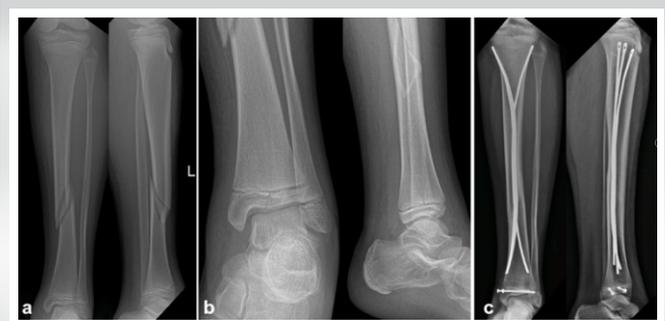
(a) Long-leg AP and lateral radiographs taken on presentation, showing spiral tibia shaft fracture with normal-looking ankle. (b) Dedicated ankle AP and lateral images show undisplaced triplane fracture. (c) Final AP and lateral radiographs following Enders nailing for tibia and percutaneous screw fixation for triplane fracture.
